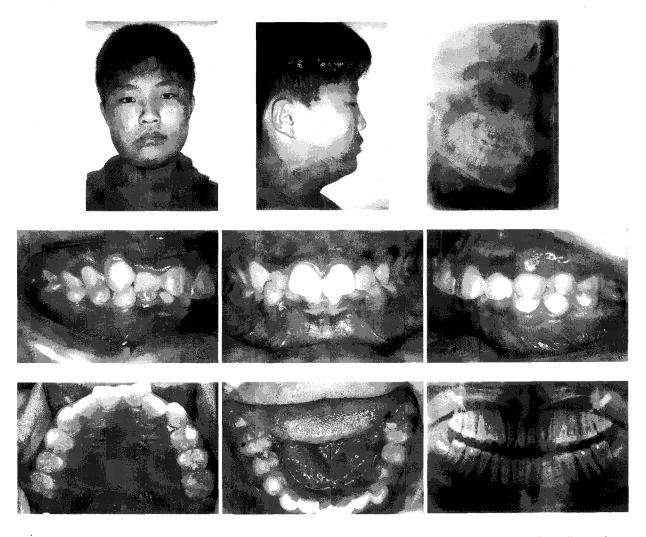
Initial facial photos, lateral cephalometric radiograph, intraoral photos, and panoramic radiograph.
